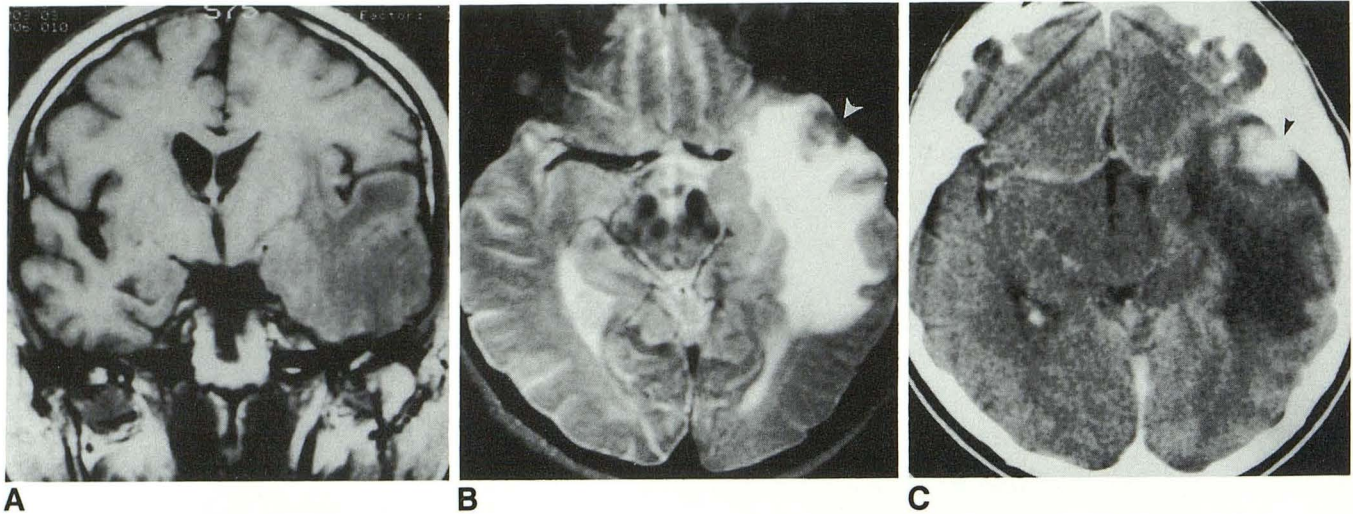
A, A T1-weighted (600/20) coronal MR image in patient 2 shows a large hypointense area in the left temporal lobe with significant mass effect.
